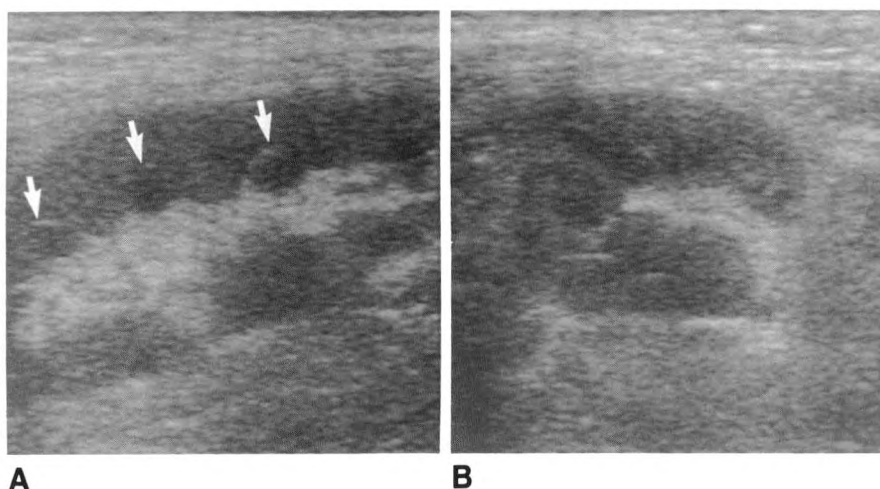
Longitudinal (A) and transverse (B) normal sonograms in a patient with a renal allograft and a normal renal biopsy. Arrows show normal medullary pyramids.
